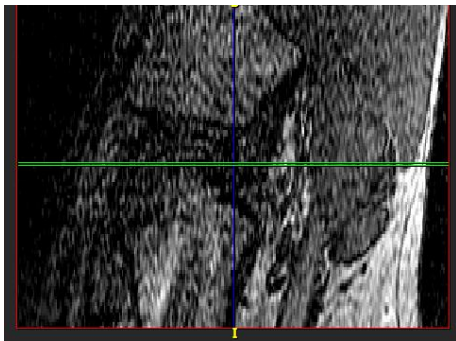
CAD model construction using MR images data collection
